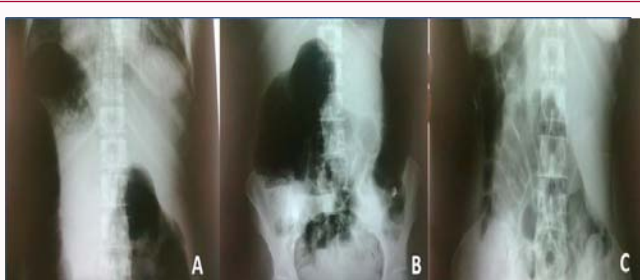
Multiple plain abdomen X-ray showing (A): marked abdominal distension (Day 2); (B): massive abdominal distension and multiple fluid levels (paralytic ileus) (Day 3) and (C): normal plain abdomen X-ray (Day 5).
